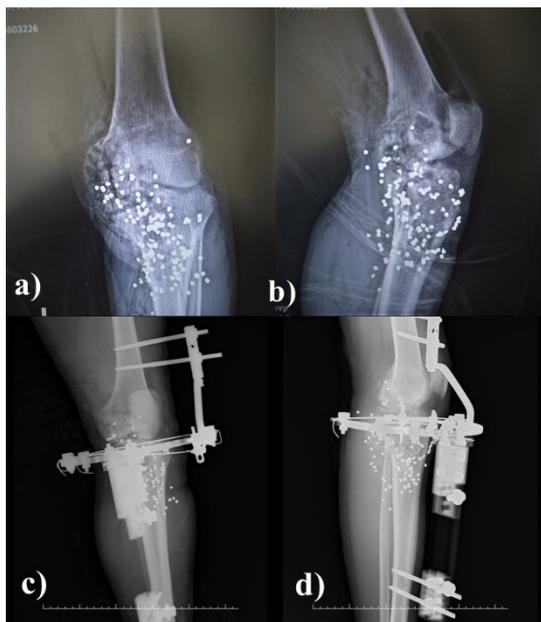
Tibial plateau Schatzker type VI fractures treated with closed reduction and external fixator: Preoperative and postoperative appearance; a) anterior posterior, b) lateral radiography (respectively).
